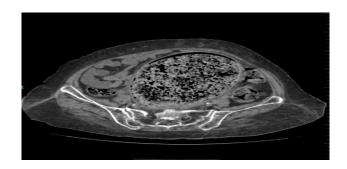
Axial view of the abdominal CT.
